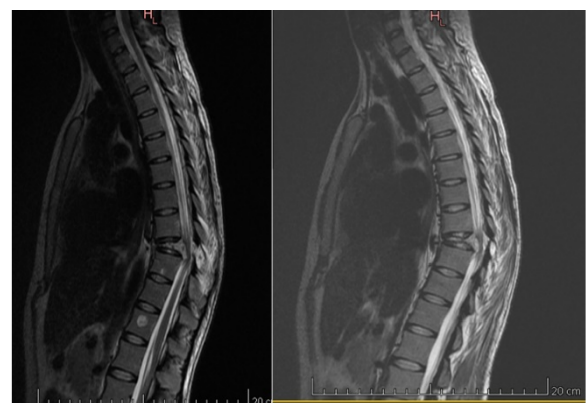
Sagittal CDL MRI: T9 vertebral body compression with cuneiform appearance, recoil of a bone segment at the level of the post wall, posteroinferior intracanal with compressive effect on the dural sac, focal lesion of 6/7 mm with osteolytic character at the level of 1/3 ext. and upper vertebral body T10.
